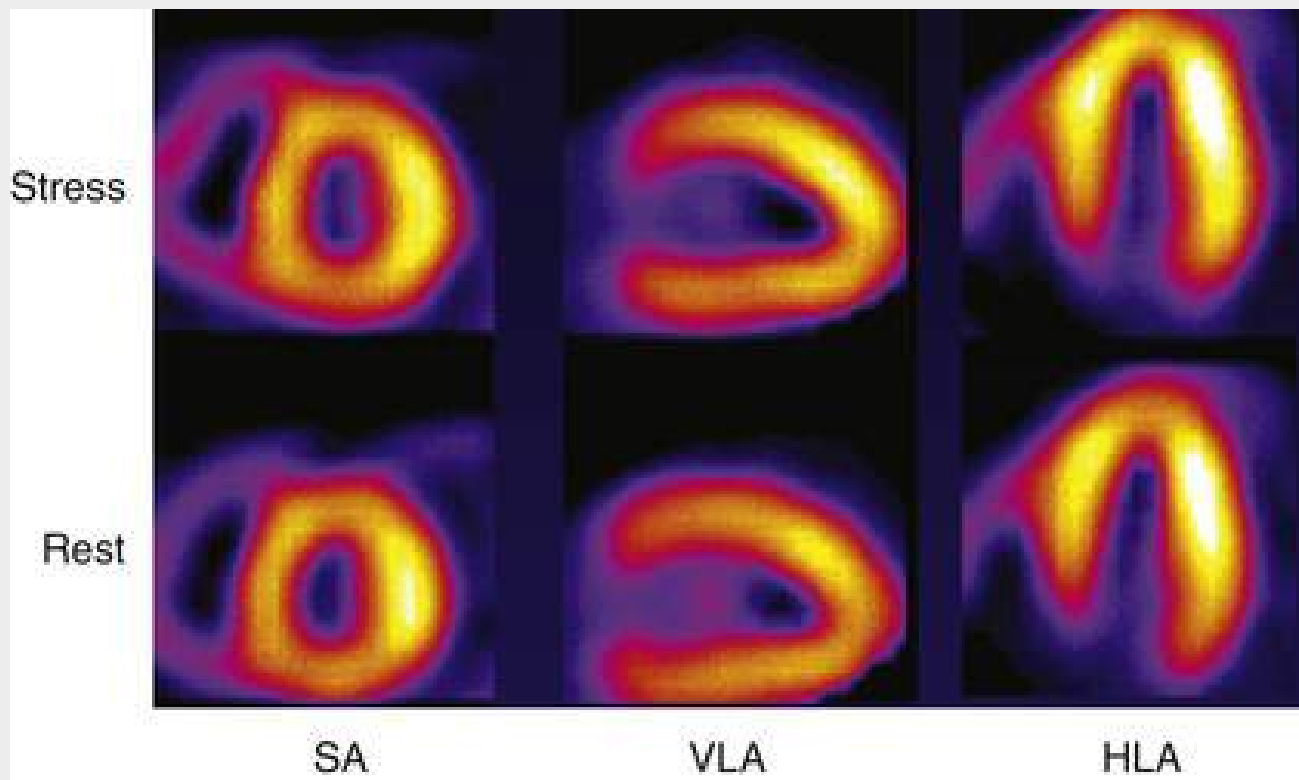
SPECT perfusion images obtained during stress and at rest in a patient with heart failure. The images depict a dilated left ventricle but with normal perfusion patterns, suggesting a low likelihood that CAD is the cause of heart failure. *HLA*, Horizontal long axis; *SA*, short axis; *VLA*, vertical long axis.
